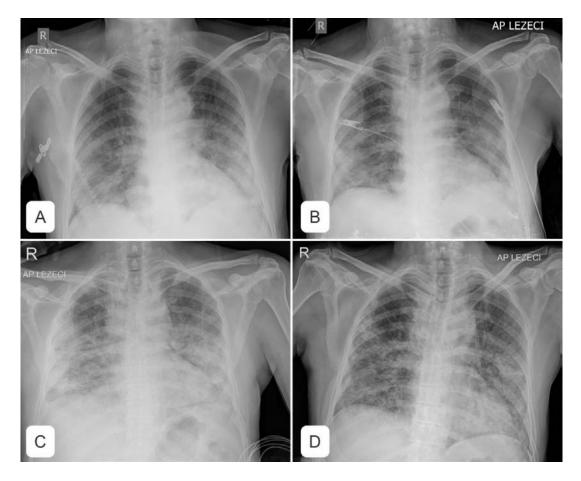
X-ray finding of the lungs: A) First day; B) Day 7; C) Day 15: D) Day 35
